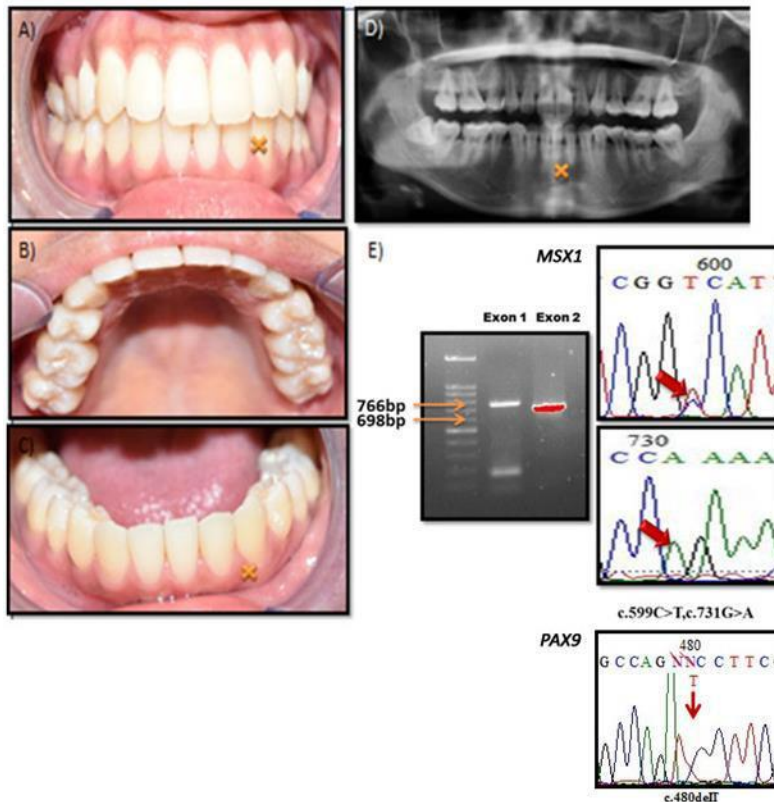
shows sample 1D (second daughter, proband) of the family clinical findings (A, B, showing missing 32; radiographic findings (D) of the respective missing tooth are indicated with 'X'; and genetic findings (E) of electrophoresis and chromatogram show point mutations on exon 1 of MSX1 c.599C>T and c.731G>A and exon 3 of PAX9 c.480delT
